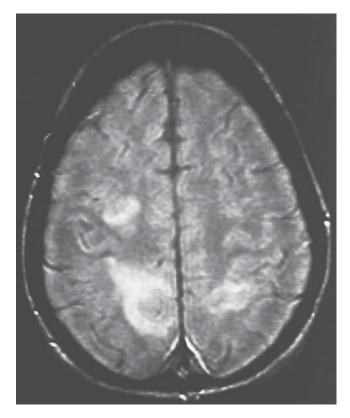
Brain magnetic resonance imaging (MRI) study showing multiple strokes in a young woman with antiphospholipid antibodies, strokes, and seizures, from Khamashta 2000, with kind permission from Springer.
